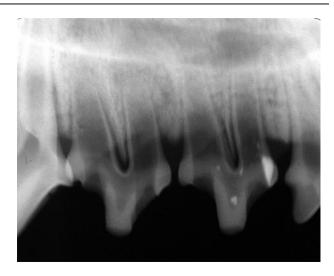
Radiograph showing root canals after 3 weeks with evidence of periapical lesion formation.
